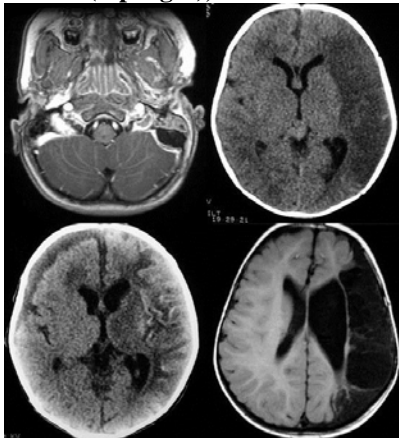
CT subdural effusion (left) can evolve into a subdural empyema (middle) which is seen as hyperintense compared to CSF on T1-weighted MRI (right)
